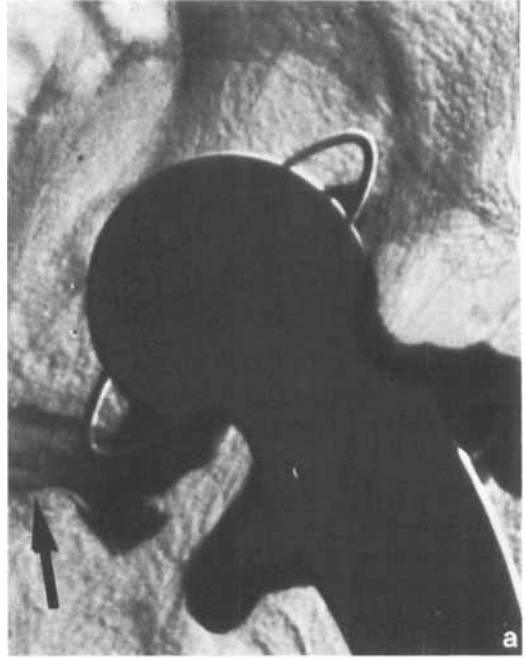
(Case 2). a. Left hip arthrogram demonstrating loosening of the acetabular cup (arrow). b. CT scan of the left hip reveals a large defect of the medial acetabular wall (arrow). This necessitated bone grafting prior to insertion of a further prosthesis.
